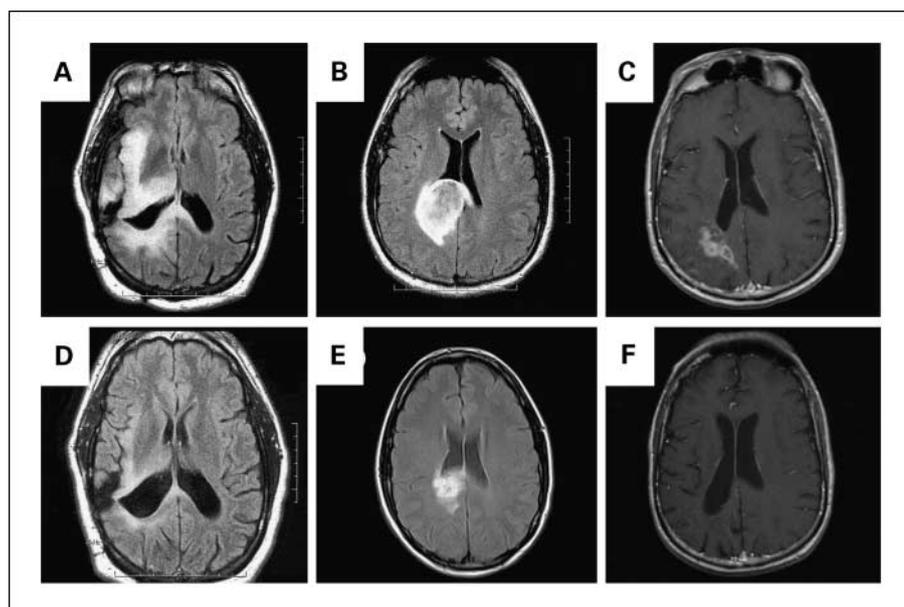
Magnetic resonance imaging responses of low-grade glioma. *A, D*, FLAIR sequences of 42-year-old with recurrent oligoastrocytoma before (*A*) and after six cycles of temozolomide (*D*). FLAIR, fluid attenuated inversion recovery. *B, E*, FLAIR sequences of 36-year-old with recurrent low-grade astrocytoma, before (*B*) and after six cycles of therapy (*E*). *C, F*, T1-weighted postcontrast sequences of a 56-year-old diagnosed with low-grade oligoastrocytoma in 1990, treated with radiation and then recurring in 2002 with enhancement (*C*). Biopsy of the enhancing lesion showed low-grade glioma and after treatment with six cycles had a near complete response of the enhancing disease (*F*).
